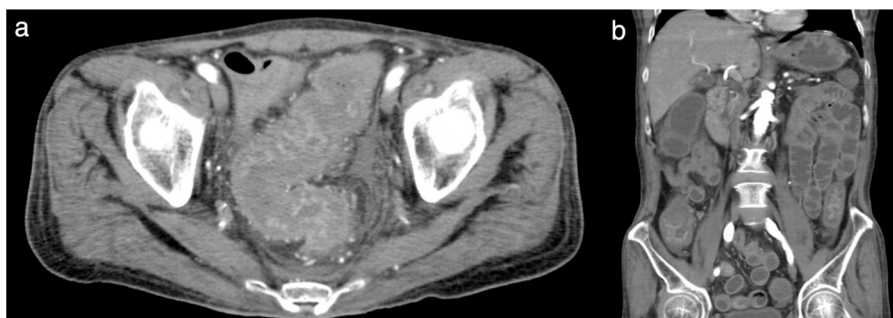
(a) Pelvic computed tomography scan at the level of the sigmoid colon. Remarkable mucosal edema was confirmed in the circumference of the sigmoid colon. (b) Abdominal and pelvic computed tomography scan (coronal view) showing severe whole-intestine edema.
